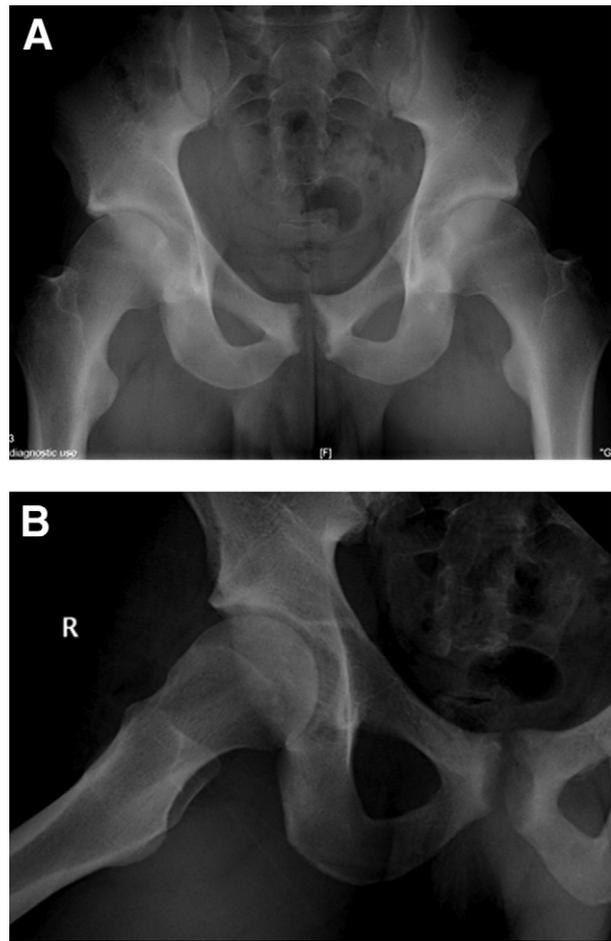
(A) Anteroposterior and (B) Dunn lateral radiographs of right hip showing loss of femoral offset and focal cephalad retroversion of acetabulum consistent with FAI in a football player with groin pain.
